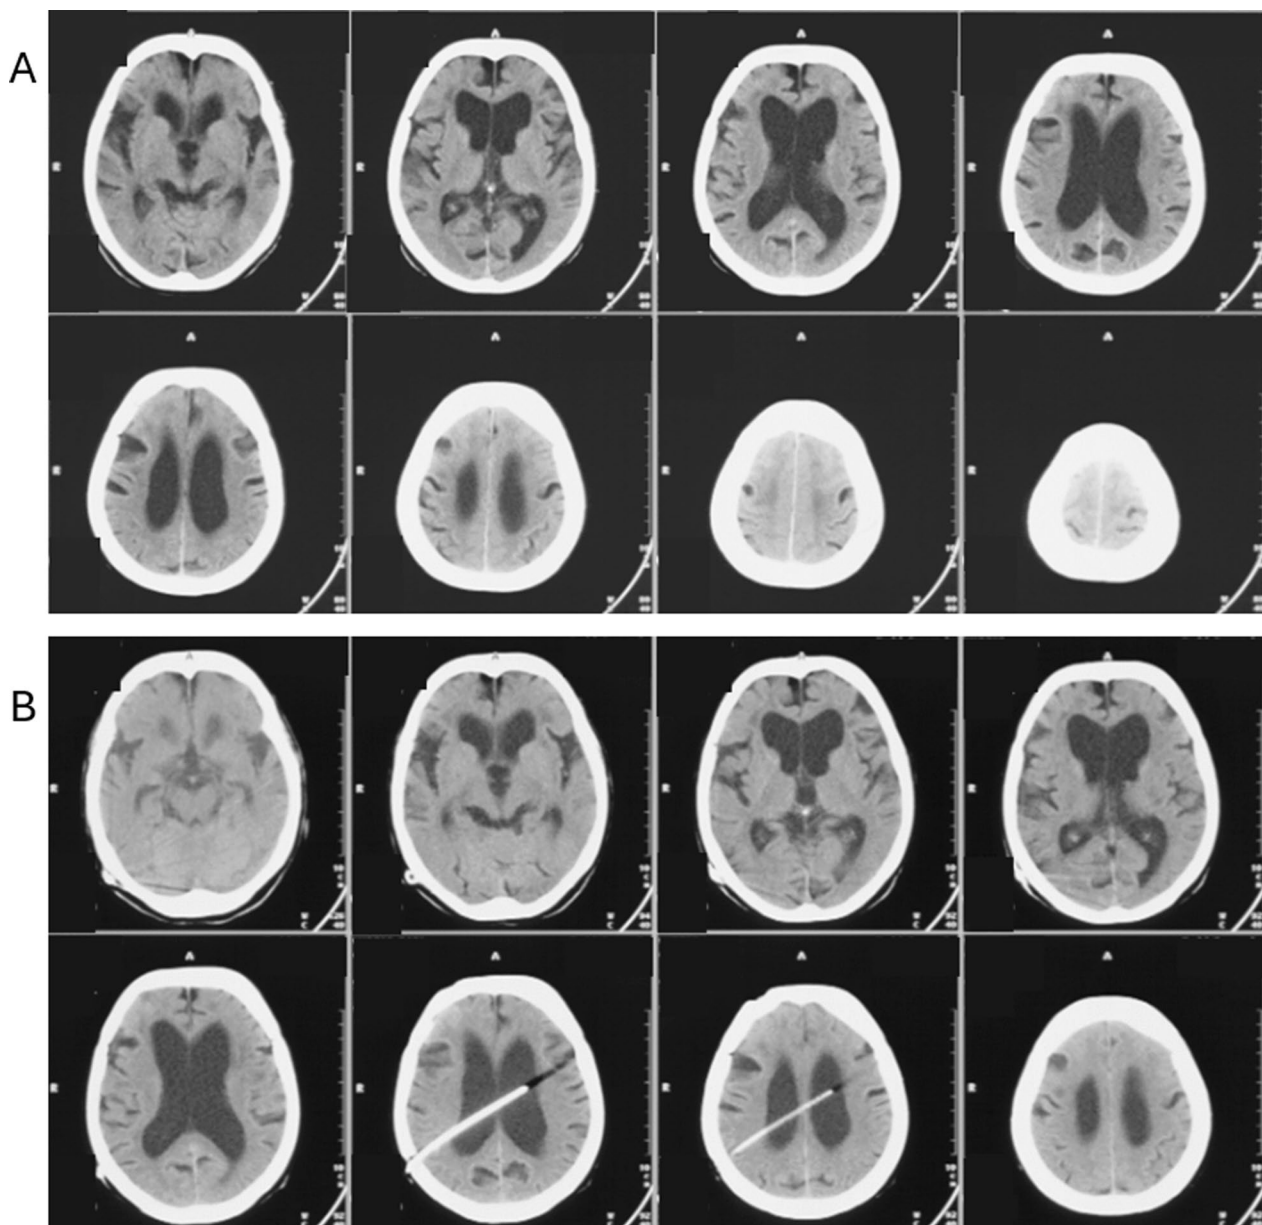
Brain images of a shunted iNPH patient harboring homozygous *CWH43* Leu533Ter (4:49032652 CA/C). A CT scans at the time of diagnosis. B Post-shunt surgery CT scans. Axial plane images show features of iNPH (enlarged brain ventricles, DESH and tight high convexity sulci)
